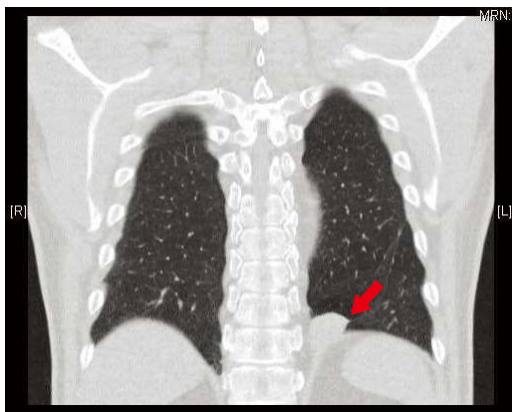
Initial chest CT, indicating a solid mass in the LLL.
